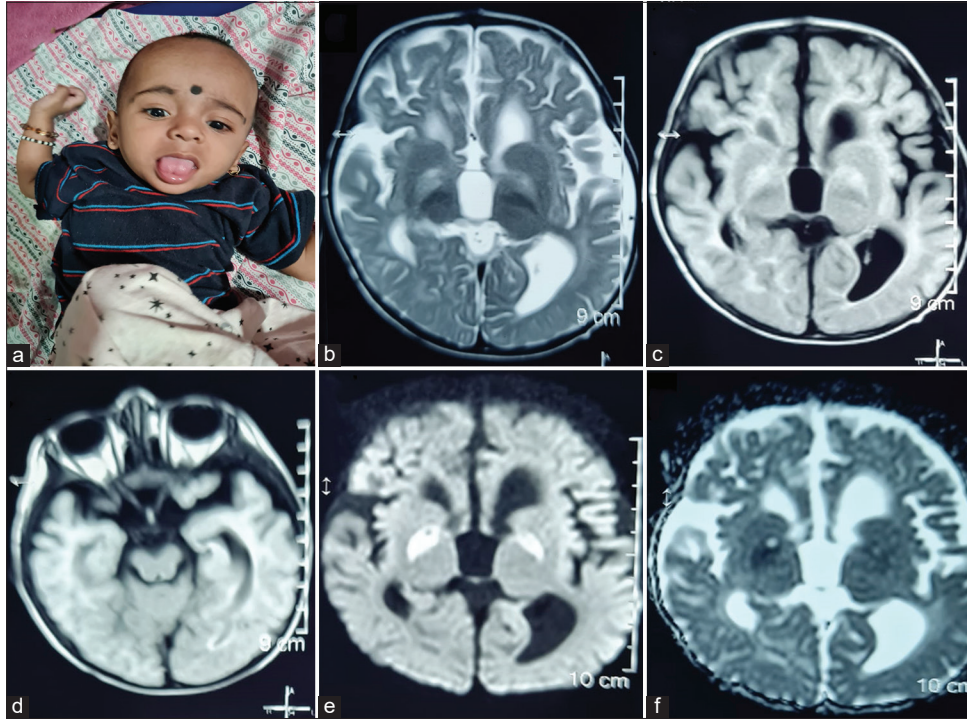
(a) Clinical photograph of the child showing tongue and upper limb dystonia, (b) axial T2-weighted (Two headed arrow), (c) fluid-attenuated inversion recovery sequences of magnetic resonance imaging of brain images showing bilateral symmetrical globus pallidus hyperintensity, bilateral basal ganglia atrophy, predominantly involving globus pallidus (left more than right) (Two headed arrow), (d) cerebral peduncles appear normal (Two headed arrow), (e) axial diffusion weighted images (DWIs) (Two headed arrow) show restriction of diffusion in bilateral globus pallidus, with hyperintensity on DWI images and (f) hypointensity of corresponding apparent diffusion coefficient maps (Two headed arrow).
